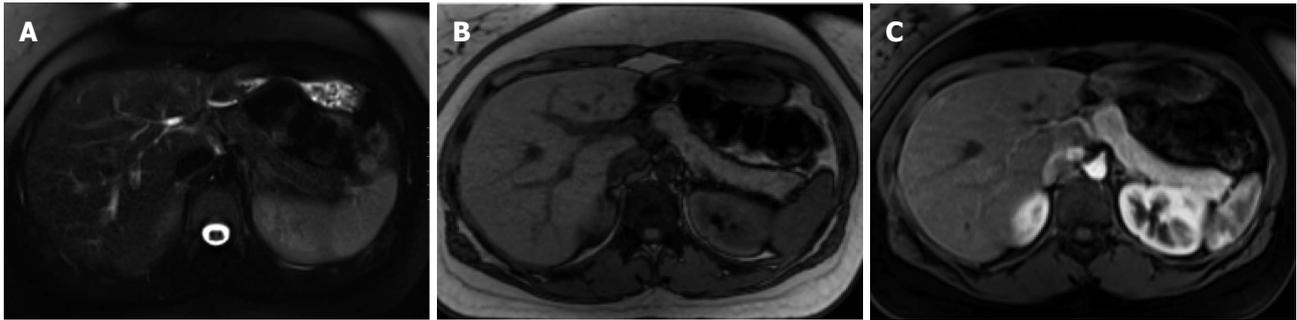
Normal pancreatic appearance on magnetic resonance imaging. A: Axial T2-weighted image with fat-suppression; B: Axial GRE out-of-phase T1-weighted image; C: Axial post-contrast 3D-GRE T1-weighted image with fat-suppression during the late arterial phase. The pancreas demonstrates low T2 signal intensity (A) and high T1 signal intensity on pre-contrast images (B), reflecting high protein content of the exocrine gland. The pancreas demonstrates avid homogenous enhancement on immediate post-contrast images (C), reflecting a normal capillary blush.
